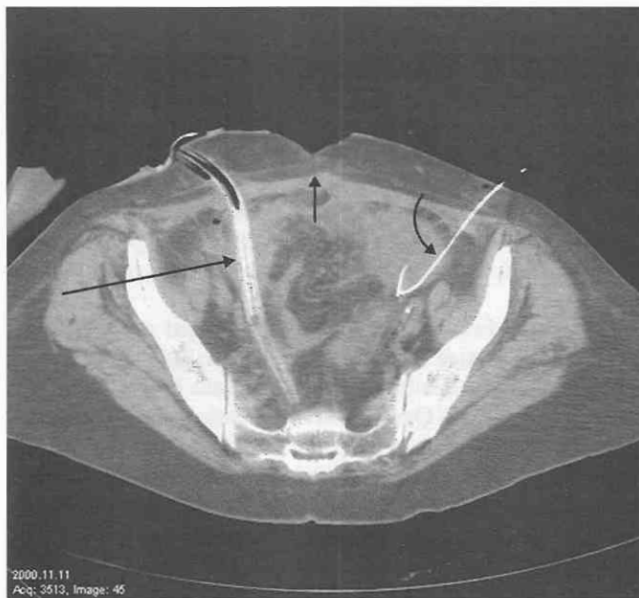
Patients with drainage catheters, high-density metallic material, and surface wounds are still suited for CT procedures. This scan shows aspirator of an abscess in a patient with surgical drains (*long arrow*) and skin defects (*small arrow*). Although the scan is not of superior quality, the visualization of the wire (*curved arrow*) used to insert a drain in the abscess is quite easily accomplished.
